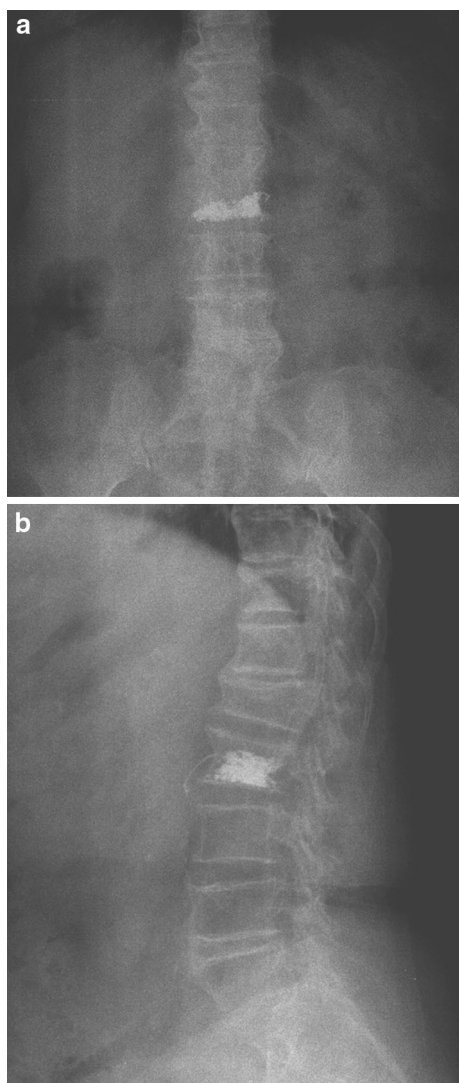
a, b Postoperative anteroposterior and lateral X-ray images of the patients
